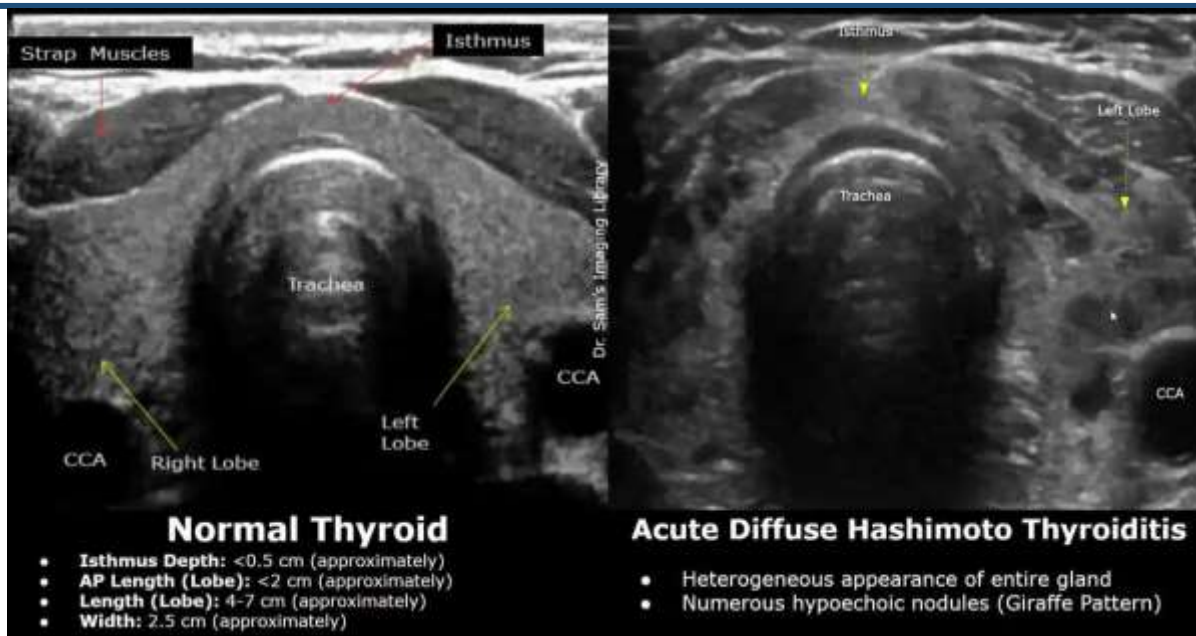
Ultrasound Appearance of Normal Thyroid and Diffuse Hashimoto's Thyroiditis: The image compares a normal thyroid gland with acute diffuse Hashimoto's thyroiditis. The affected gland shows heterogeneous echotexture and multiple hypoechoic areas, characteristic of autoimmune inflammatory changes.
